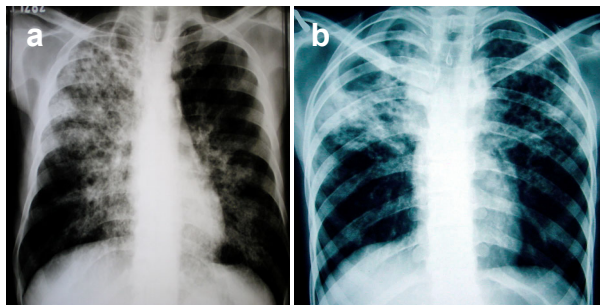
Chest X-ray showing parenchymal infiltrate and cavitation in the right upper lobe (a) and in both upper lobes (b) (Reproduced from Melo 2005b).
